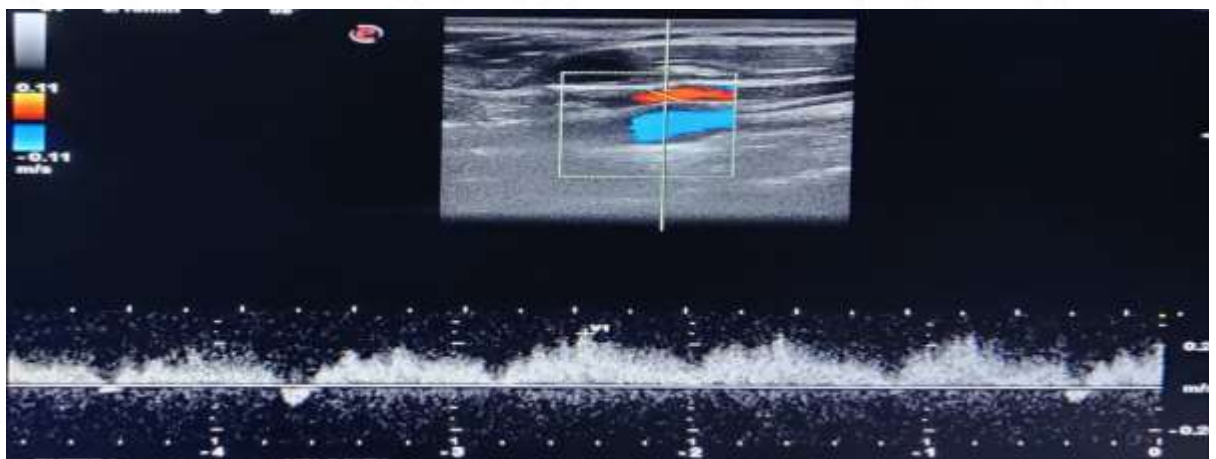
shows Pulsed wave doppler of the right internal jugular vein (IJV) at the level of cricoid cartilage in longitudinal section.
